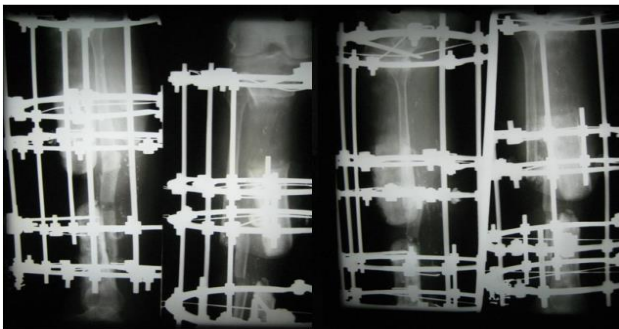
X-ray following bone transport with gradual distraction at the proximal corticotomy site.
